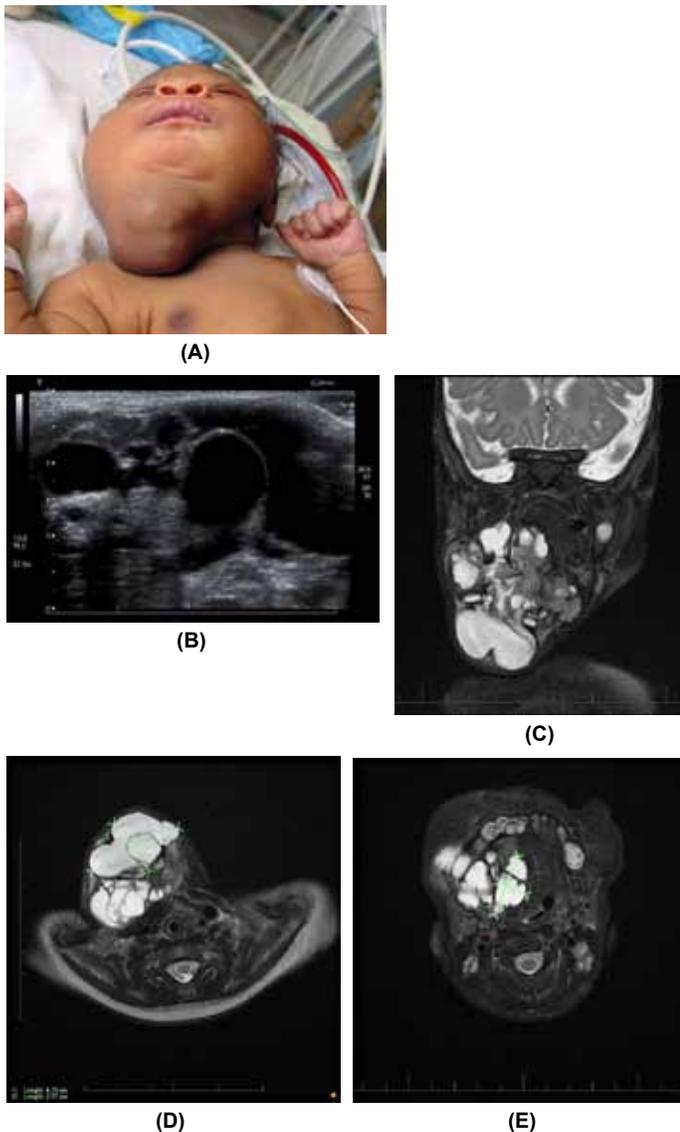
Difficulties in diagnosis: (A) A large lobulated neck mass in a newborn. (B) US showing multicystic lesion; patient was initially observed, but was readmitted with feeding difficulty. (C) MRI (coronal view, T-2 weighted) showing extent in the floor of the mouth. (D) Axial view demonstrating an intact trachea. (E) Proximally, the mass displacing the larynx and base of the tongue. The patient failed two attempts at sclerosis with doxycycline and required nasogastric tube feedings and a tracheostomy following an episode of bronchiolitis. Excision carried out at 5 months of age revealed a mature teratoma.
